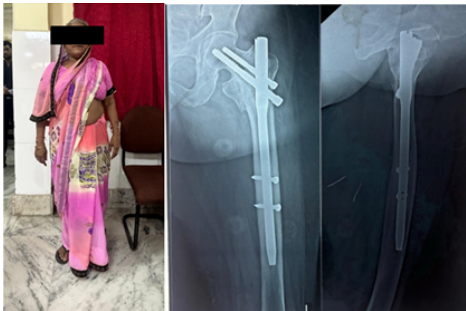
Months Follow Up Clinical Picture And Xray
